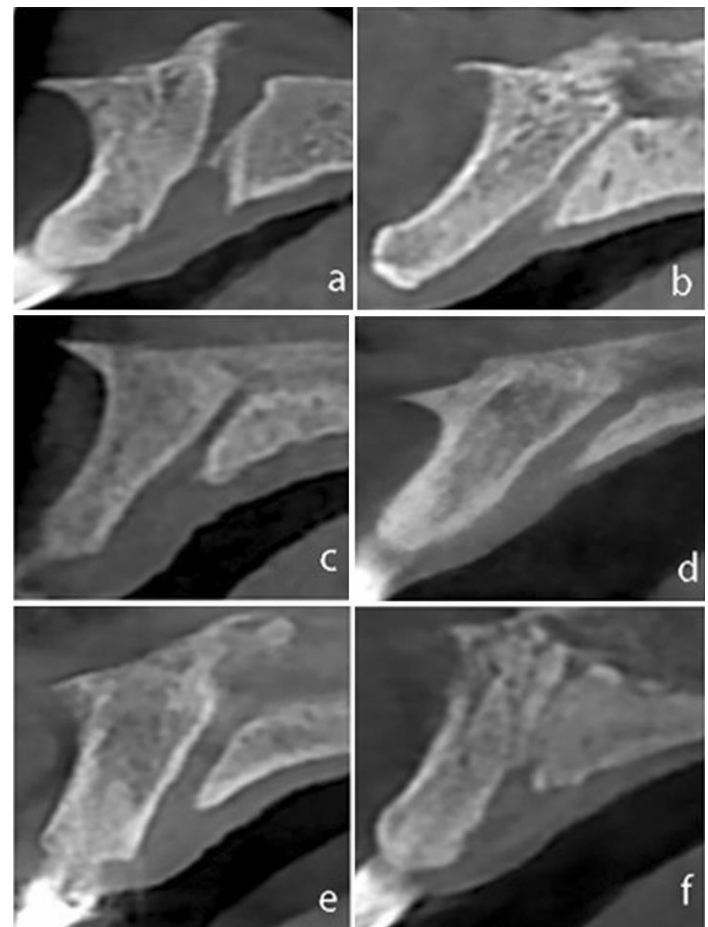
Classification of nasopalatine canal shape in the sagittal section of CBCT images a. Hourglass, b. Conical, c. Funnel, d. Cylindrical, e. Tree branch
